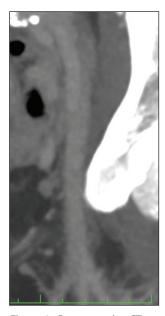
Postoperative CT showed a patent EIV and CFV.
